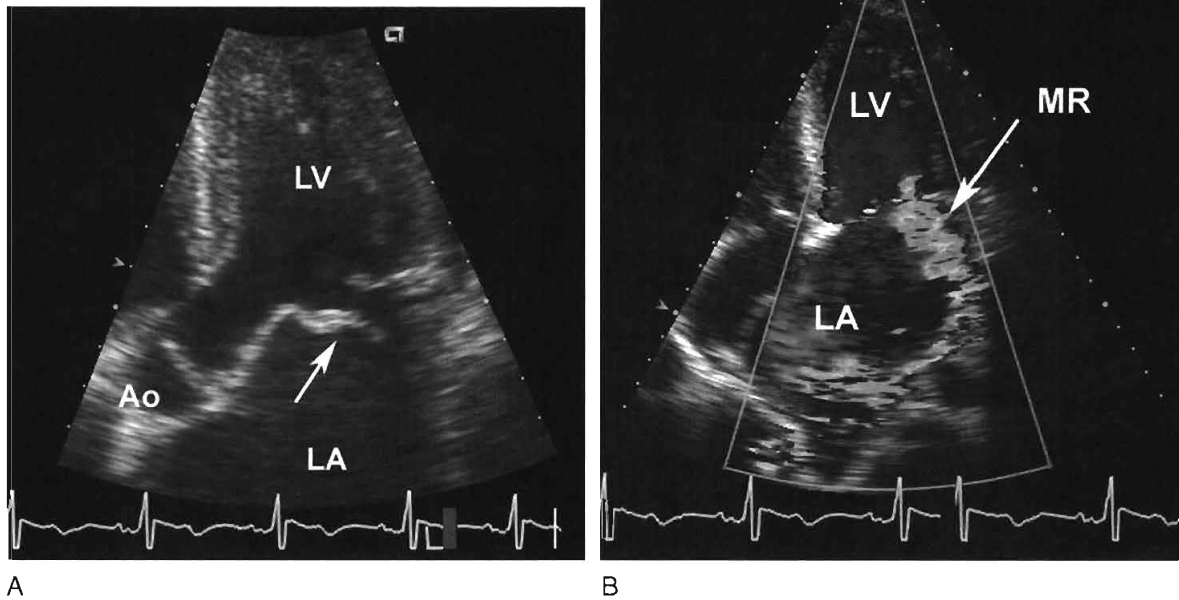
In this 24-year-old man with chronic mitral prolapse, chordal rupture resulted in a flail anterior leaflet seen in an apical four-chamber view (A, arrow). Severe mitral regurgitation (MR) was seen with a posterior and laterally directed jet on Doppler color flow imaging (B, arrow). Ao, aorta; LA, left atrium; LV, left ventricle. (See Color Section in this text.)
